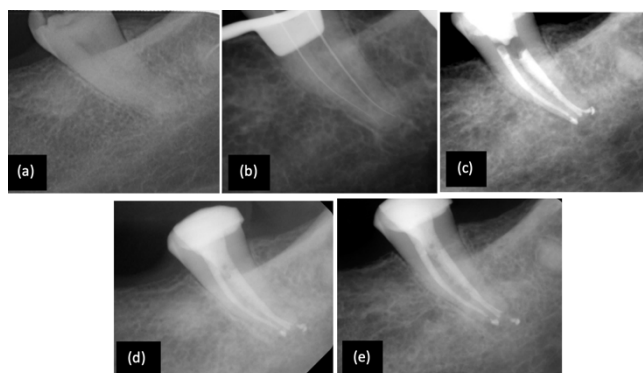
A 45-year-old female patient was referred to an endodontics clinic to continue the root canal treatment (RCT) of tooth 37 due to difficult morphology. Tooth 37 was diagnosed as previously initiated RCT with asymptomatic apical periodontitis. (a) pre-operative radiograph. (b) Working length determination radiograph. (c) Post-operative radiograph. (d) 1year follow-up. (e) 2 years follow-up, RCT was successful.
